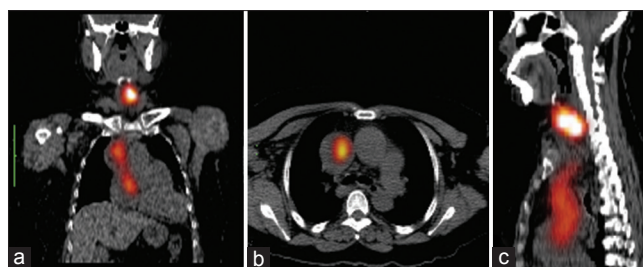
Fused single photon emission computed tomography coronal, axial and sagittal (a-c) images of postradioiodine-131 therapy (5.6GBq) in 2015 showing intense uptake in the thyroid bed, superior vena cava and right atrium
